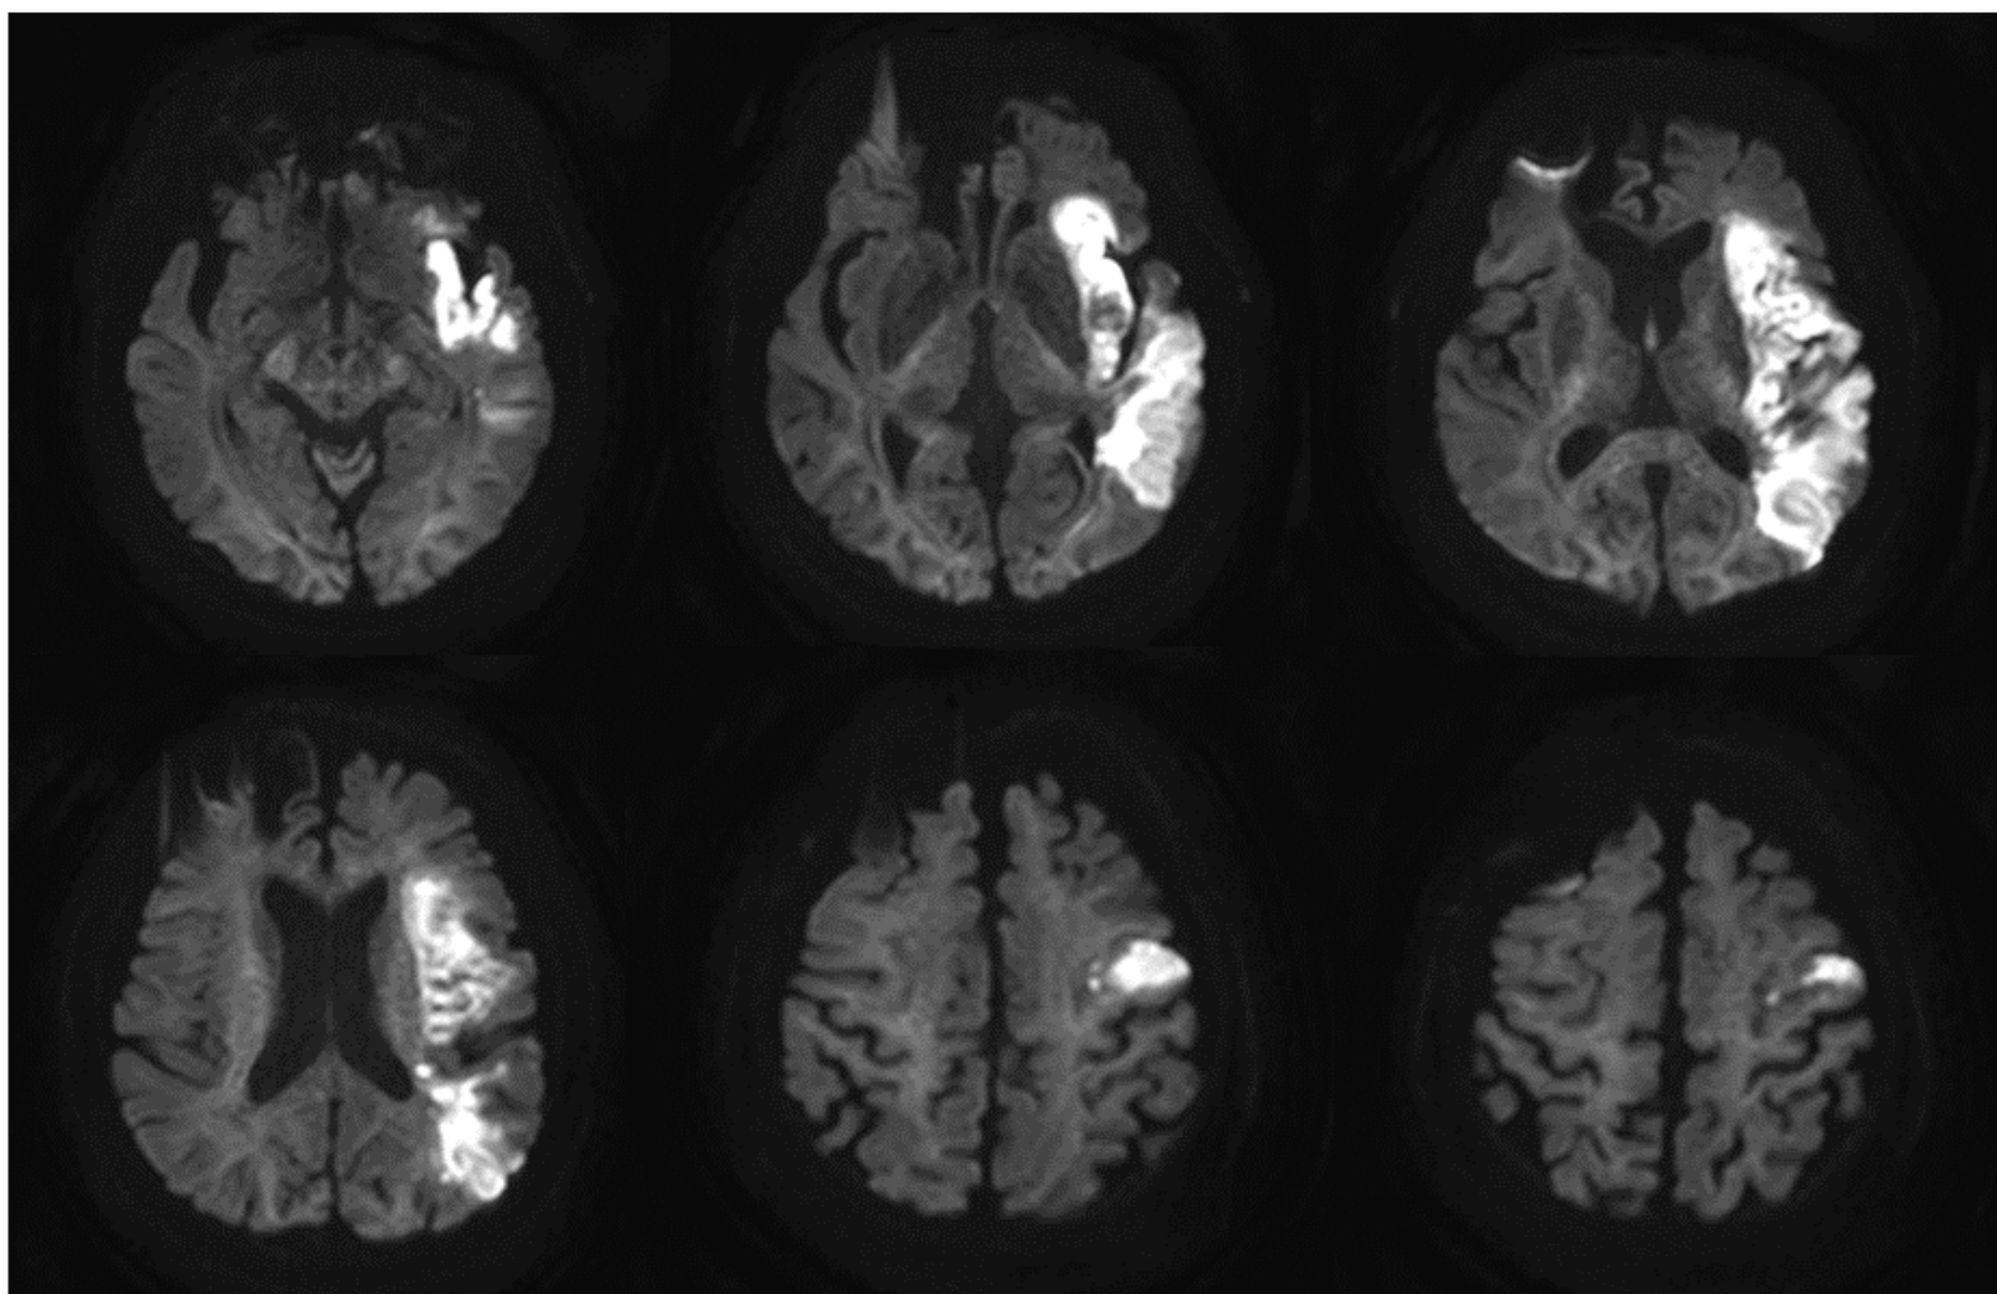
Brain Magnetic Resonance Imaging of a 59-year-old male patient with Severe swallowing apraxia
